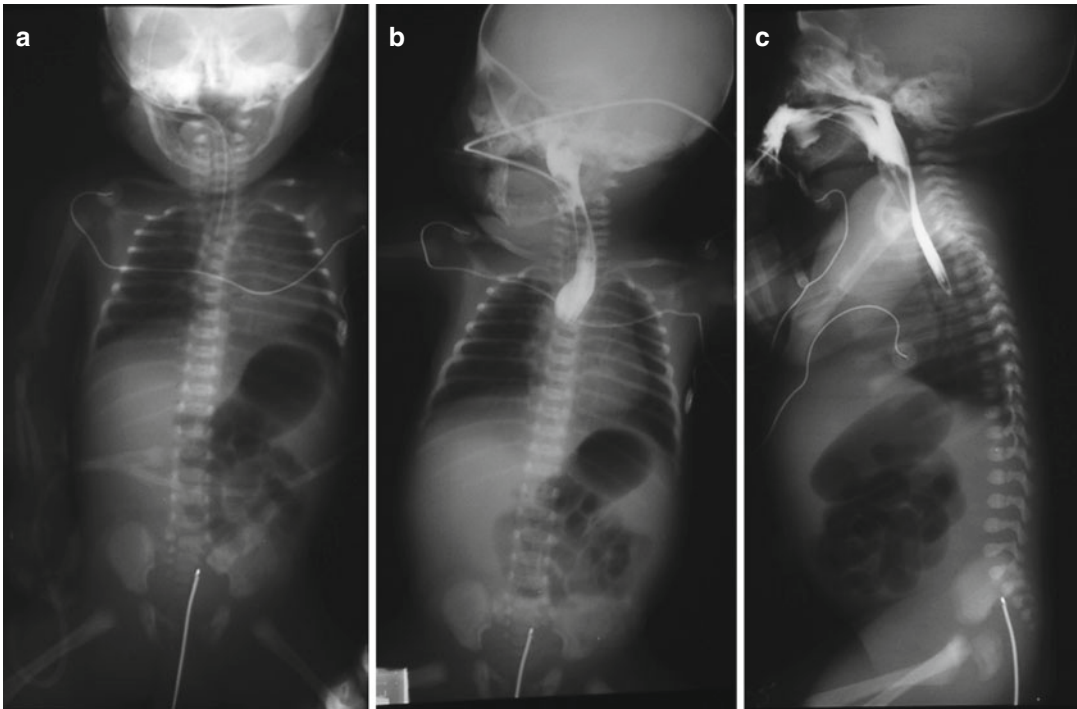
Esophageal atresia with lower fistula. (a) Frontal radiograph shows the nasogastric tube arresting within the upper esophageal pouch. It is clearly depicted in air
